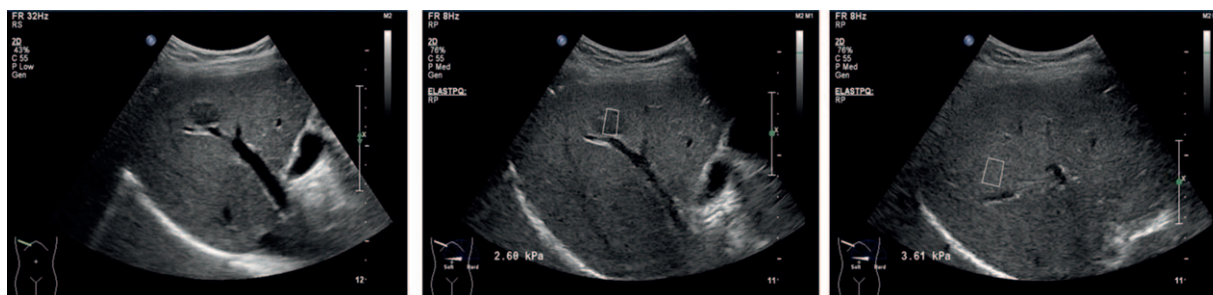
In vivo stiffness measurements of 26 patients with mass-like focal fatty changes (FFCs). Stiffness measurement of a mass-like focal fatty change and its background liver displayed over B-mode ultrasound images. The white boxes represent regions of interest for stiffness measurement.
